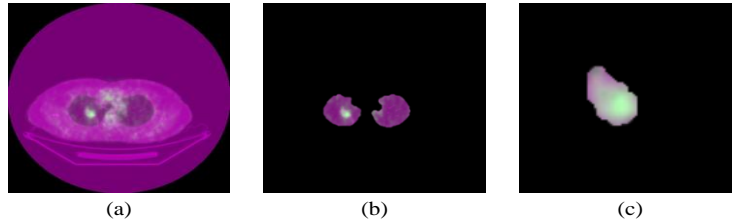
The results obtained using the multi-scale circular template matching algorithm. (a) shows the results of registration based on the MI of the original lung CT images; (b) shows the results of registration for lung parenchyma images; and (c) shows the nodule results area obtained using the circular template matching algorithm shown in (b).
